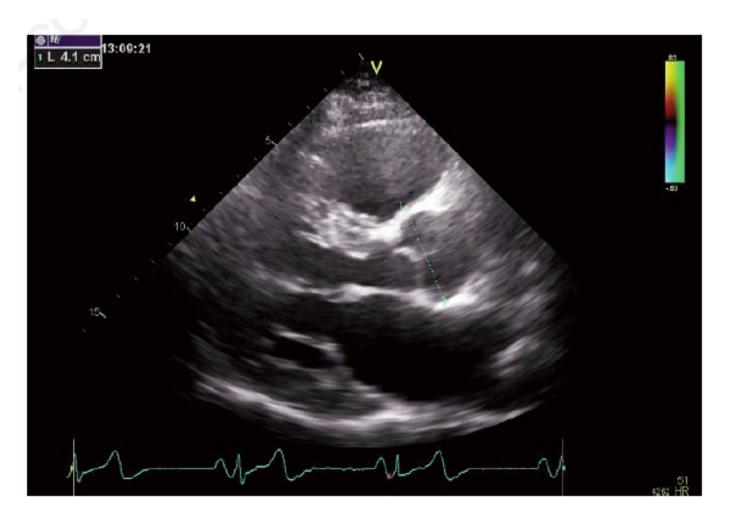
A parasternal long axis view of a Fabry patient's heart. Please note the mildly dilatated aortic root and left atrium.
